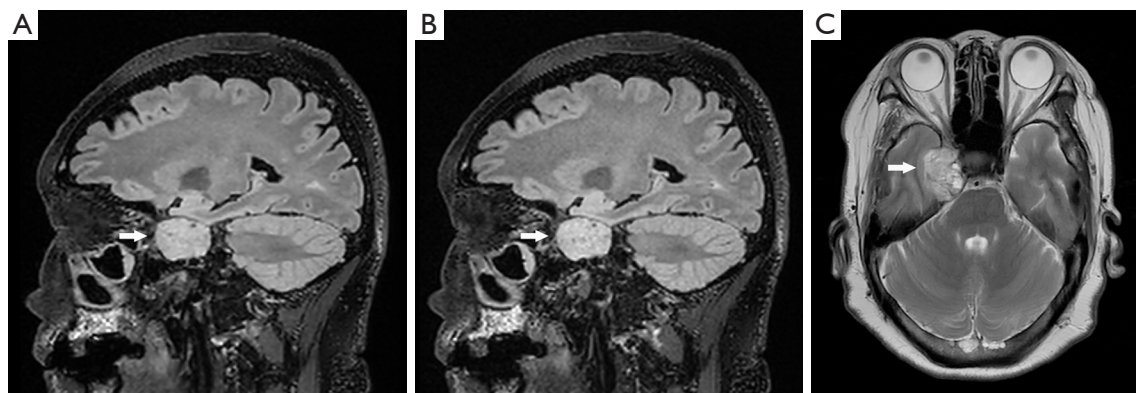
ACS-3D T2 FLAIR and PI-3D T2 FLAIR images of a metastatic tumor near the left occipital lobe in a 72-year-old female patient (with the original cancer being small-cell lung cancer). (A) ACS-3D T2 FLAIR sagittal view showing a heterogeneous-intensity lesion (black arrow). (B) PI-3D T2 FLAIR sagittal view of the same lesion (black arrow). (C) Transverse T2WI of the metastatic tumor (black arrow). A slight movement of the patient between the PI acquisition and ACS acquisition led to misalignment between the original PI FLAIR slices and original ACS FLAIR slices. ACS, artificial intelligence-assisted compressed sensing; 3D T2 FLAIR, three-dimensional T2 fluid-attenuated inversion recovery; PI, parallel imaging; T2WI, T2-weighted imaging.
